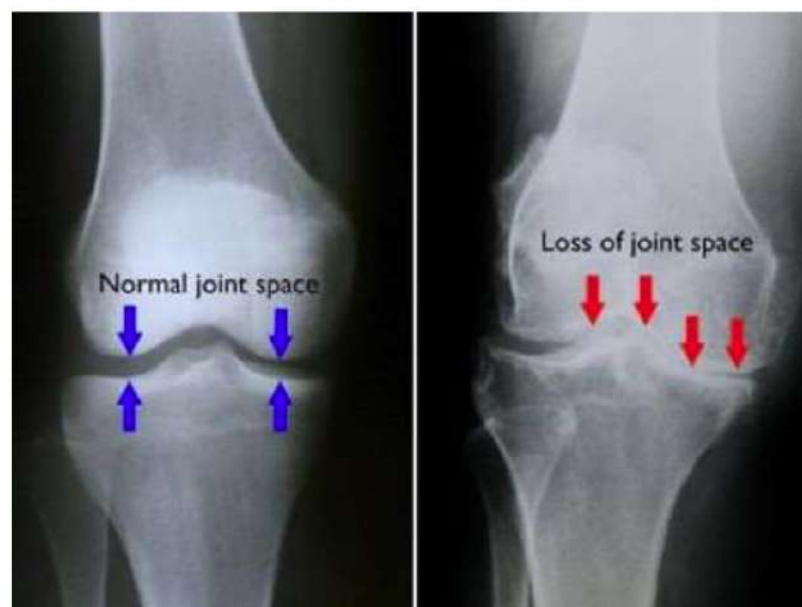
(Left) In this x-ray of a normal knee, (Right) severe loss of joint space.
